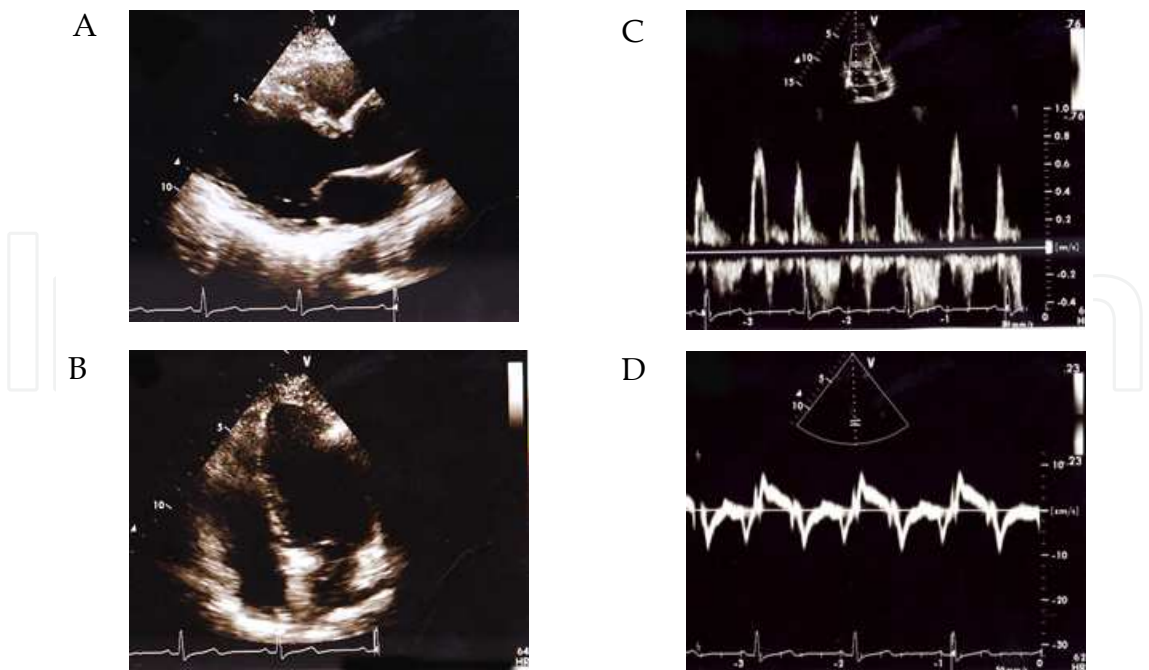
Normal pattern in LV inflow: Panel A shows long axis view. Panel B shows 4 chamber view. Panel C shows LV inflow. Panel D shows tissue Doppler imaging.
